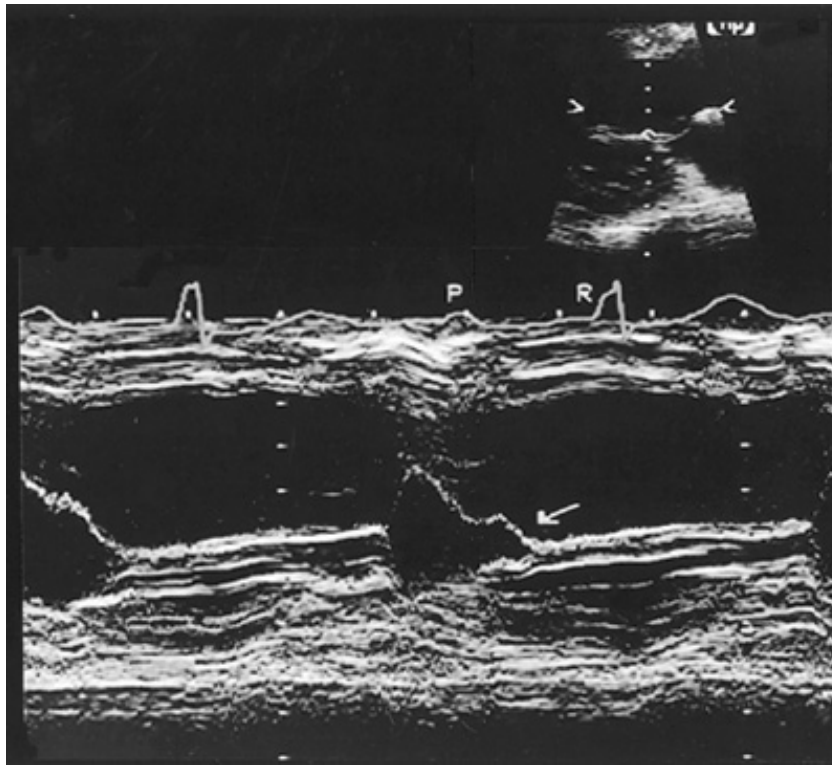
M-mode tracing (from the parasternal position) in a patient with acute severe aortic regurgitation. The mitral valve leaflets close (*arrow*) before ventricular contraction begins. P = p wave, R = QRS complex.
